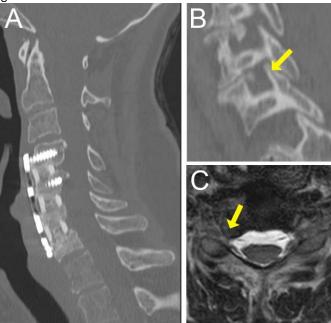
A sagittal CT scan of the cervical spine reveals radiographic fusion of the C4-7 arthrodesis construct (A). The CT scan suggests subsidence at C6/7 with right foraminal stenosis (B). An axial T2-weighted MRI reveals right C6/7 foraminal stenosis (C).
